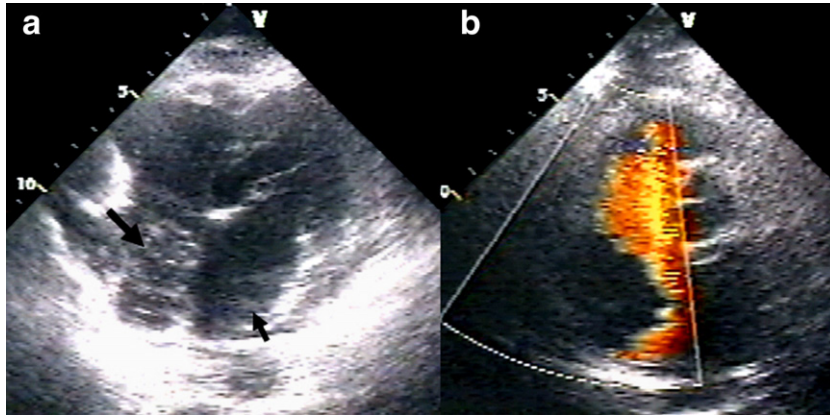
a: Echocardiography showing relatively hypoechoic masses in the right atrium (large arrow) and in the left atrium (small arrow), b: Color Doppler imaging showing that the mass obstructs the superior vena cava–right atrium inflow tract.
